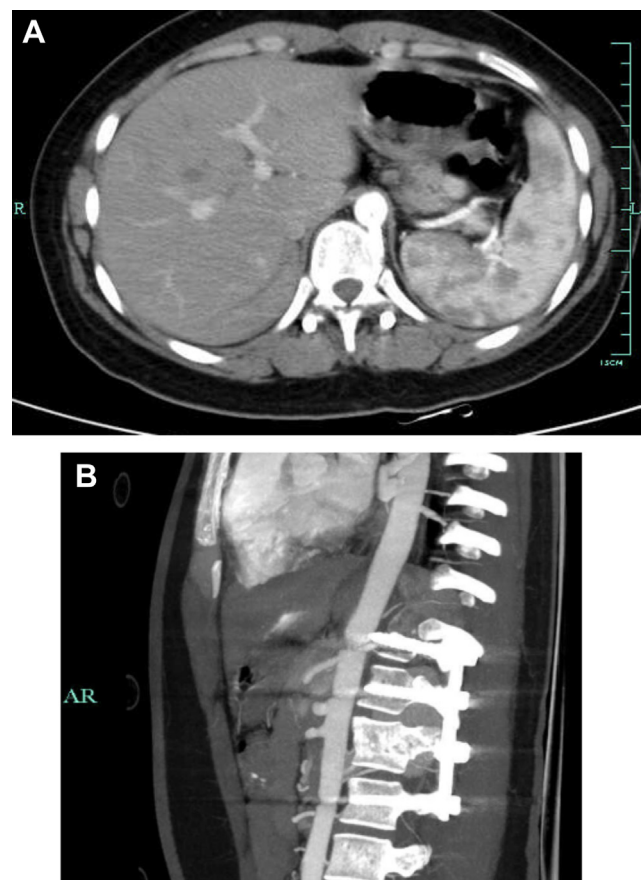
No evidence of hematoma, pseudoaneurysm formation or pleural effusion is observed in the contrast-enhanced computed tomography scan.
